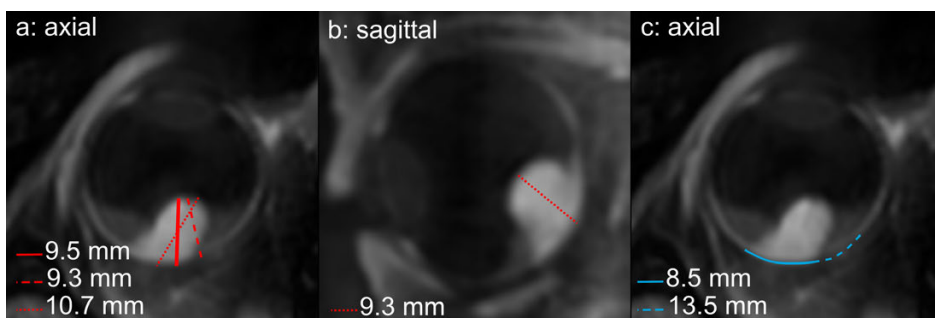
Several measuring planes on T1gd-weighted MRI for a mushroom shaped UM. (a) Three possible prominence measurements in the axial plane for a complexly shaped tumour: starting with the point closest to the centre of the eye (solid, the definition used in this study), parallel with the main tumour axis (dotted) and including the overhanging part of the tumour (dashed). (b) An evaluation of the same tumour in the sagittal plane resulted in a different measurement. (c) For obliquely oriented tumours, several base definitions are possible depending on whether the overhanging part is included as tumour base.
